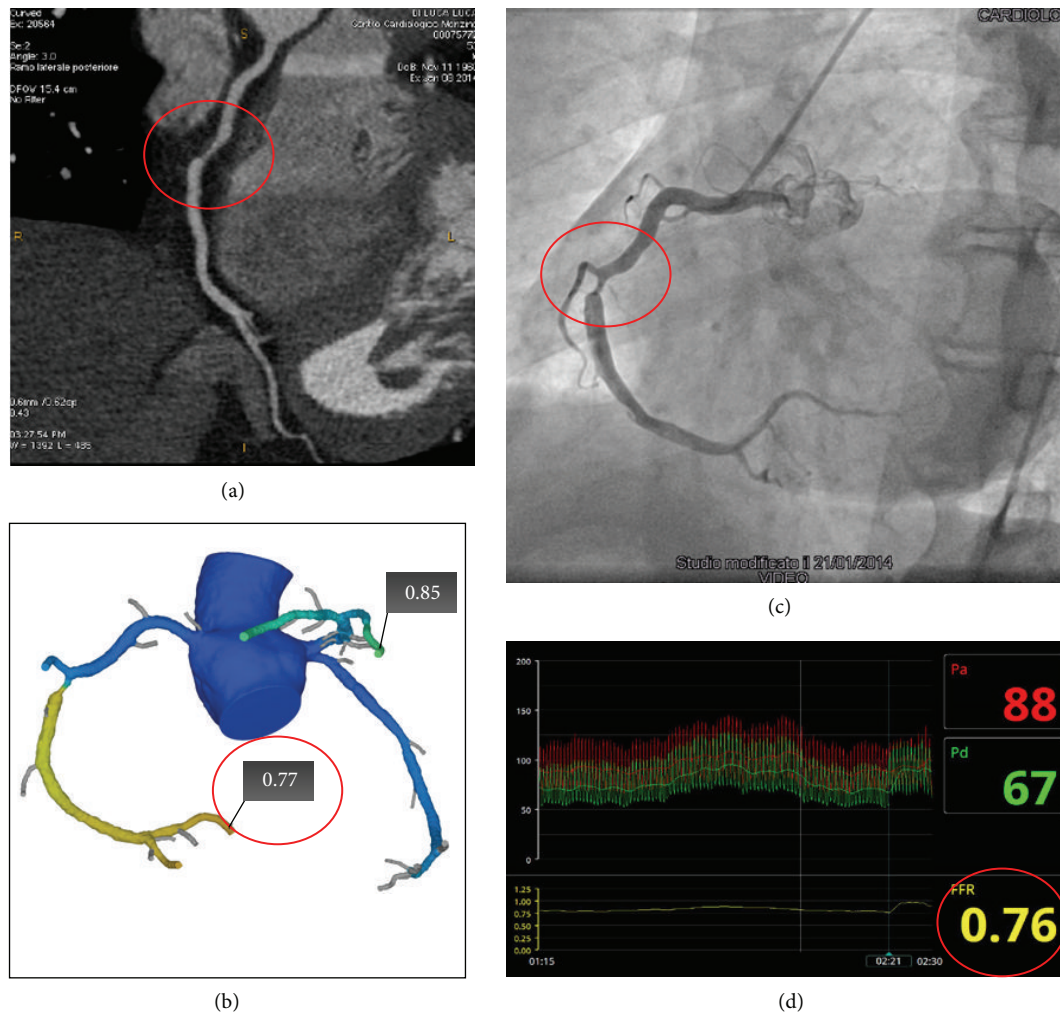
Clinical case of an intermediate risk patient symptomatic for chest pain. Panel (a) showed a multiplanar reconstruction of CCT showing an obstructive stenosis of the middle right coronary artery (red circle) and computed fractional flow reserve (FFR-CT) value of 0.77, indicating vessel ischemia (Panel (b)). Invasive coronary angiography confirmed the obstructive stenosis of the middle portion of the right coronary artery (Panel (c), red circle) and measured fractional flow reserve (FFR) values of 0.76 (Panel (d), red circle). CCT: cardiac computed tomography.
